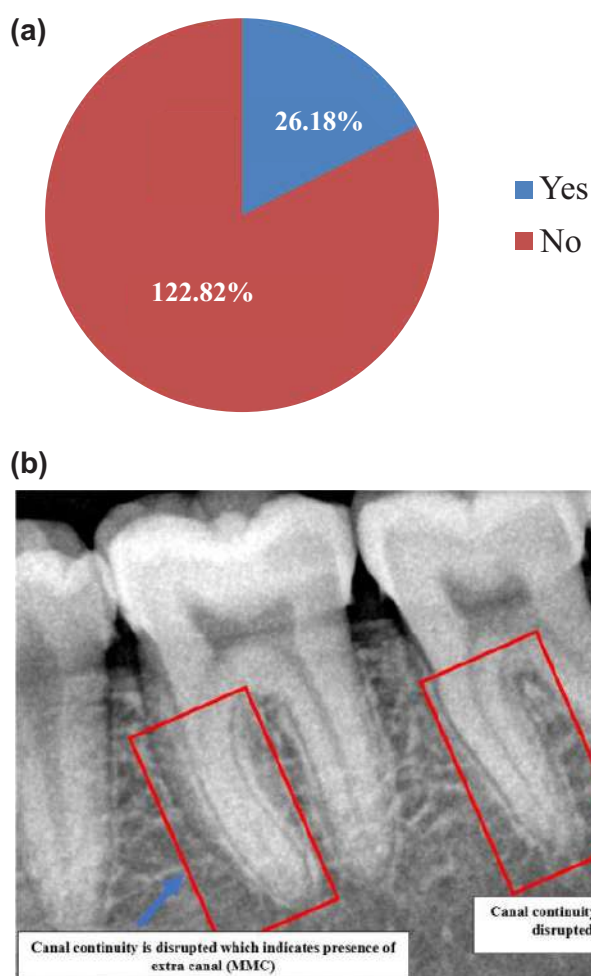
Part A Showed Frequency of MMC Found in Our Study, Part B Showed Radiograph for The Presence and Absence of MMC
